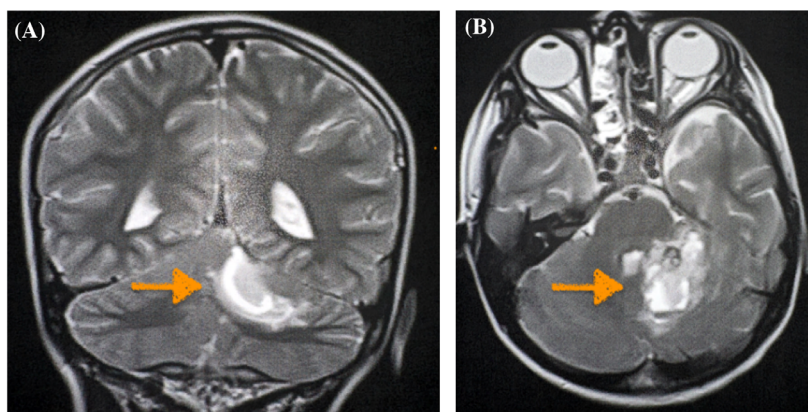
Magnetic resonance imaging of the brain with contrast, (A) coronal view and (B) axial view, demonstrating a left cerebellar hemorrhage secondary to a cavernous malformation (arrows).
